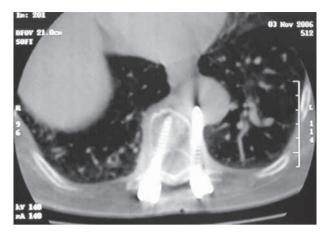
CT image of case 1 showing a left pedicle screw, which protrudes through the anterolateral wall of the T10 vertebral body and perforates the aorta.
